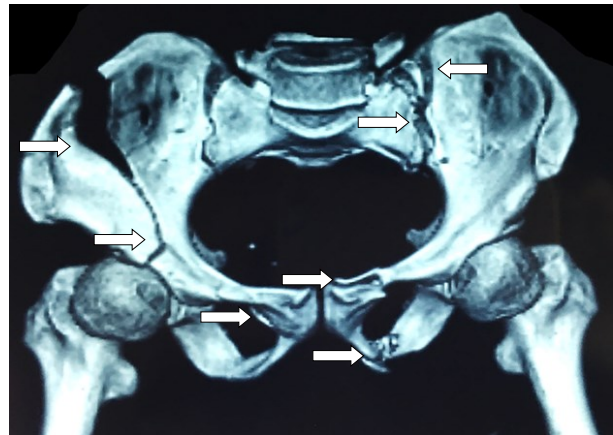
Pre-operative 3-D CT reconstruction (White solid arrows indicating points of fracture of the pelvis).
